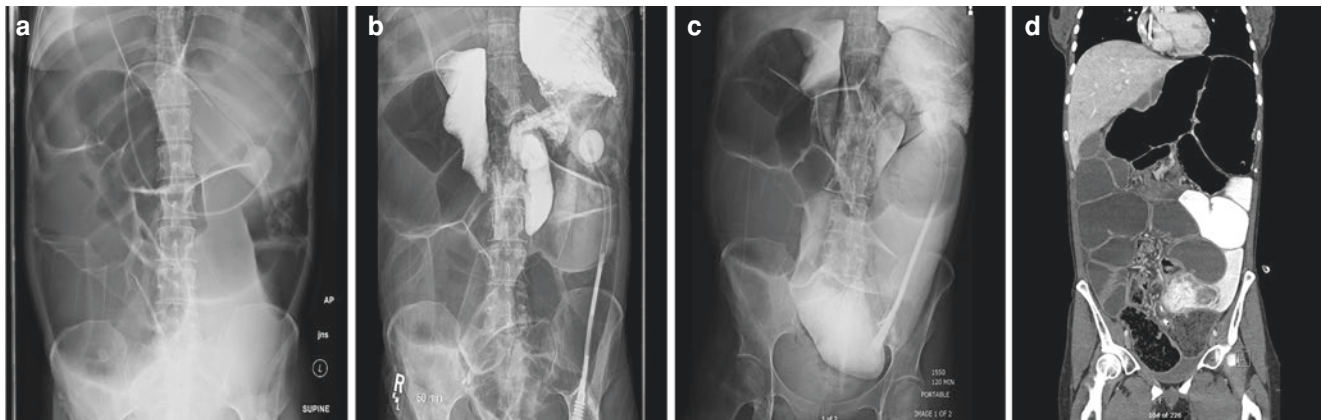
Radiologic features of gut dysmotility. (a) Plain abdominal X-ray with diffusely dilated small bowel loops with no evidence of collapsed distal bowel. (b and c) Upper GI series with retained contrast after 60 (b) and 120 (c) minutes in the stomach and proximal jejunum
